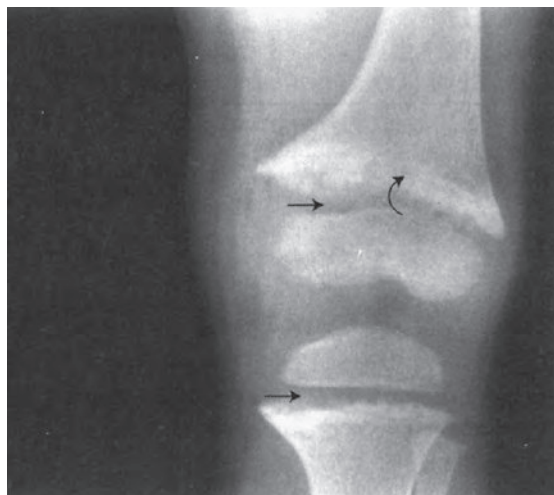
Rickets. Radiograph of the left knee joint showing widening of the growth regions of the bones (arrows).
